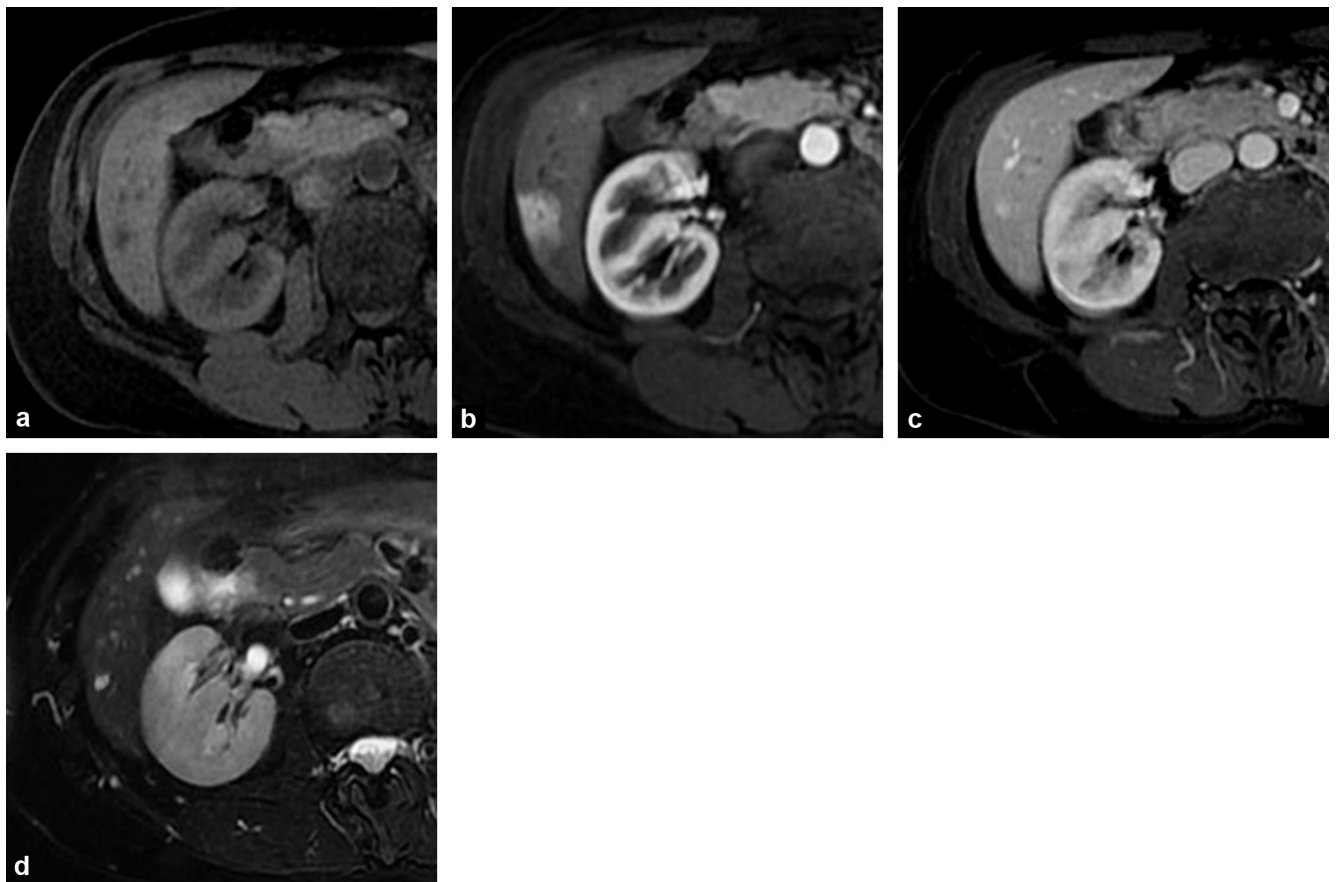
Haemangioma. Monitoring examination for cirrhosis of viral origin. T1-weighted MRI with fat saturation without (a), then after gadolinium injection in the arterial (b) and portal (c) phases and with T2-weighting (d). Hypervascular lesion in the arterial phase, with persistent enhancement in the portal phase. Note the parenchymal enhancement around the lesion in the arterial phase due to high arterial flow. The clear hyperintensity with T2-weighting confirms the diagnosis of haemangioma.
